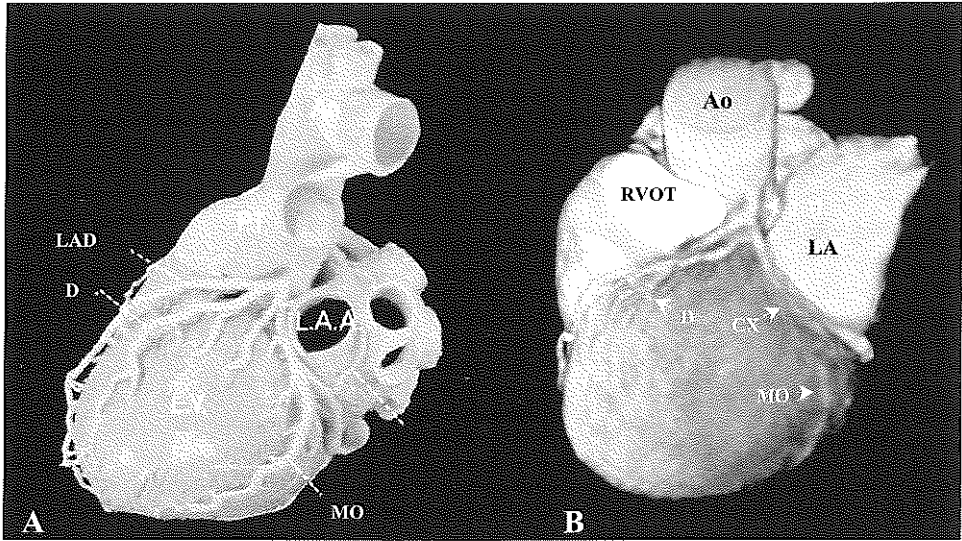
(A) Anatomical view of the left coronary artery (reproduced with permission from McAlpine.¹⁷ The auricle of the left atrium (L.A.A.) overlapping the circumflex coronary artery is removed. The left main (LM) artery divides beneath the L.A.A. in the left anterior descending (LAD) and circumflex (CX) coronary arteries. From the LAD artery diagonal branches (D) arise. The margo obtusus (MO) arises from the CX artery. (B) A comparable non-invasive coronary angiogram with respiratory-gated three-dimensional magnetic resonance imaging. Technique same as in Figure 1. Ao, aorta; PT, pulmonary trunk; LA, left atrium, after removal of the auricle; LV, left ventricle; RVOT, right ventricular outflow track.
